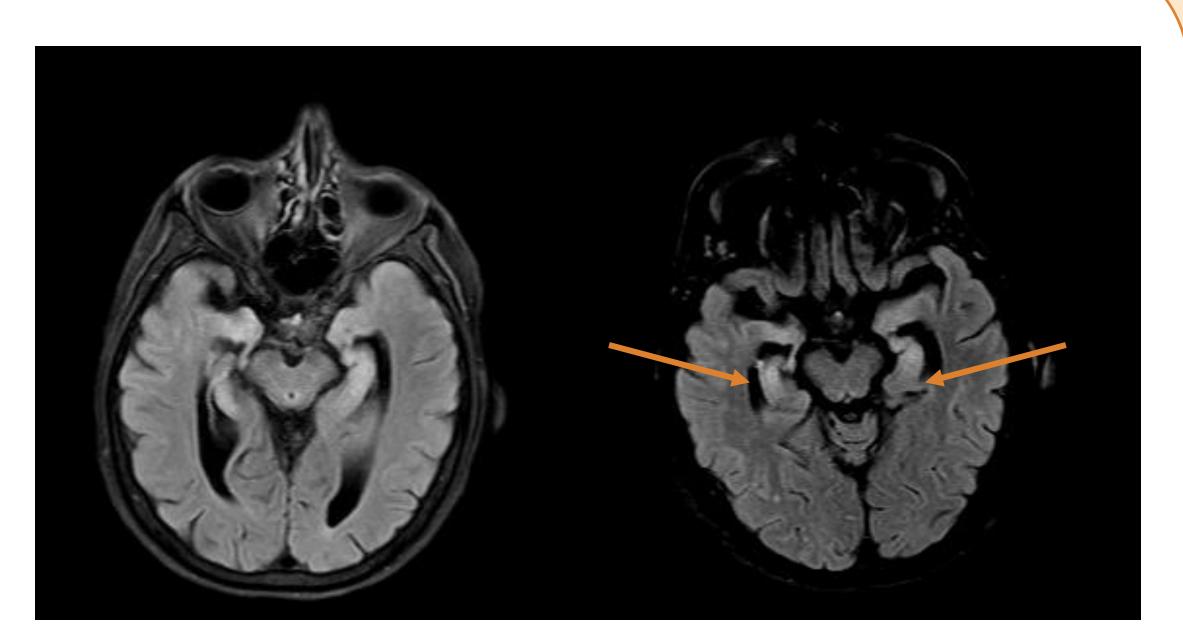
Brain MRI without contrast demonstrated persistent bilaterally hippocampal FLAIR hyperintensity (orange arrows) with worsening atrophy of the medial temporal lobes.
